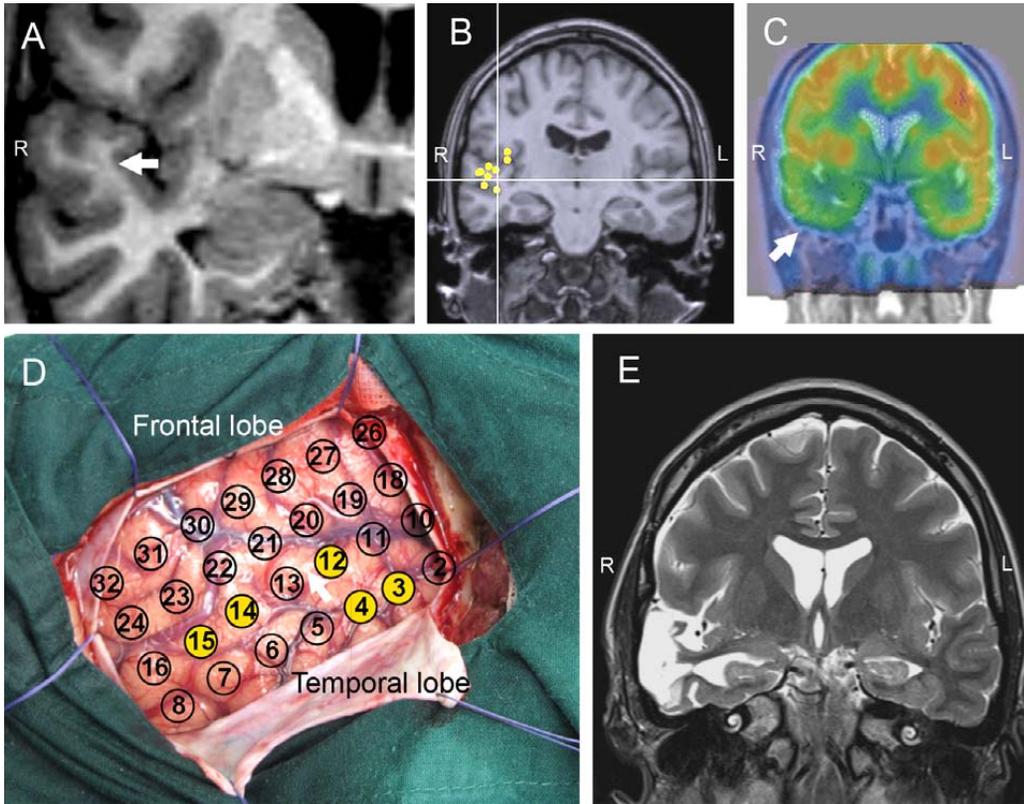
Preoperative multimodal evaluation. A 31-year-old female with partial epilepsy since the age of four and nowadays having seizures almost daily. Preoperative MRI with 1.5 Tesla did not show any abnormalities, but imaging with the 3 Tesla MRI revealed blurring of the white matter in the right upper temporal gyrus (arrow) (T1 coronal image) indicating possible focal cortical dysplasia (A). The MEG study detected interictal spikes at the same localisation (B) and FDG-PET showed hypometabolism in the lateral temporal cortical area (arrow) (C). The area of ictal onset was localised to contacts 3, 4, 12, 14 and 15 with subdurally implanted GRID-electrode (D) and the neocortical resection of temporal lobe tailored according to the ictal intracranial EEG-findings was performed in November 2009 (Arrow indicates the site of cortical dysplasia). The patient was seizure-free (Engel 1A) at the three months follow-up, and the pathological examination confirmed focal cortical dysplasia (Taylor type IIB). The postoperative MRI (T2 coronal image) showed the resection of temporal lateral cortex including the cortical dysplasia (E).
